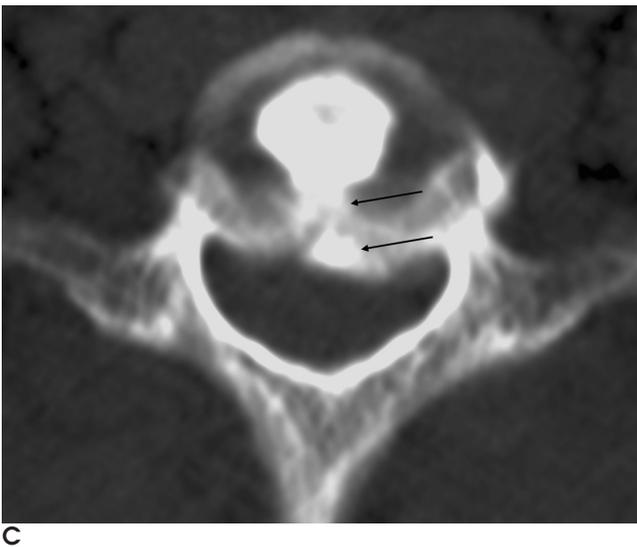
A 40-year-old man with posterior cervical pain after traffic injury showing decreased signal intensity and protrusions of disc on T2-weighted image and radial tear on CT discography (patient #7).
